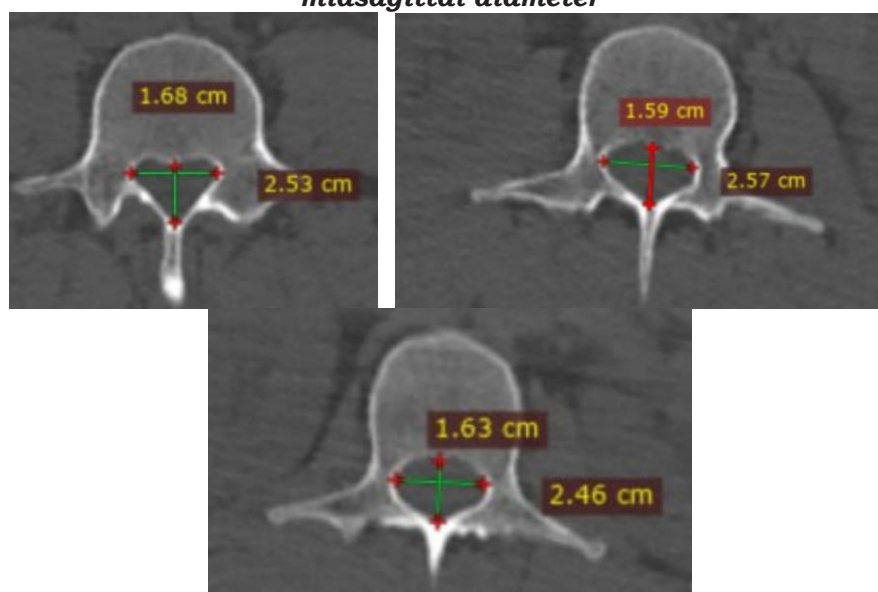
CT image showing the methods of measuring the interpedicular distance (Transverse diameter) and midsagittal diameter (Anteroposterior diameter) of male & female
